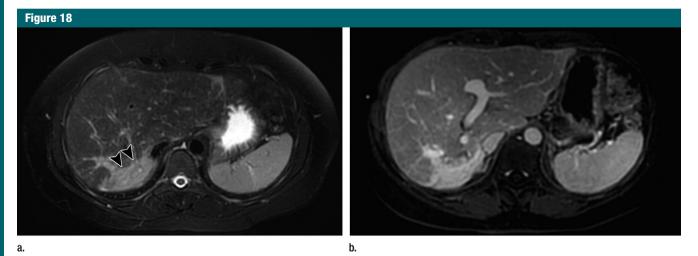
Focal confluent fibrosis in a 38-year-old woman with autoimmune cirrhosis. (a) Fat-suppressed fast SE T2-weighted MR image (2500–8000/90; flip angle, 90°; section thickness, 4 mm) shows a strongly hyperintense area in the right liver (arrowheads). At T1-weighted imaging (4.5/2.2; flip angle, 10°; section thickness, 4 mm), the lesion is strongly hypointense on unenhanced images, is isointense on arterial phase images (not shown), and (b) is strongly hyperintense on delayed phase image using non-hepatospecific MR contrast agent. Such enhancement corresponds to extensive fibrosis. Note also the atrophy of the right liver.
